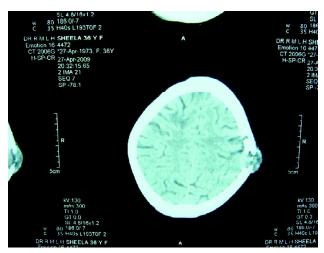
CT scan of head showing secondary metastasis in skull bone.
